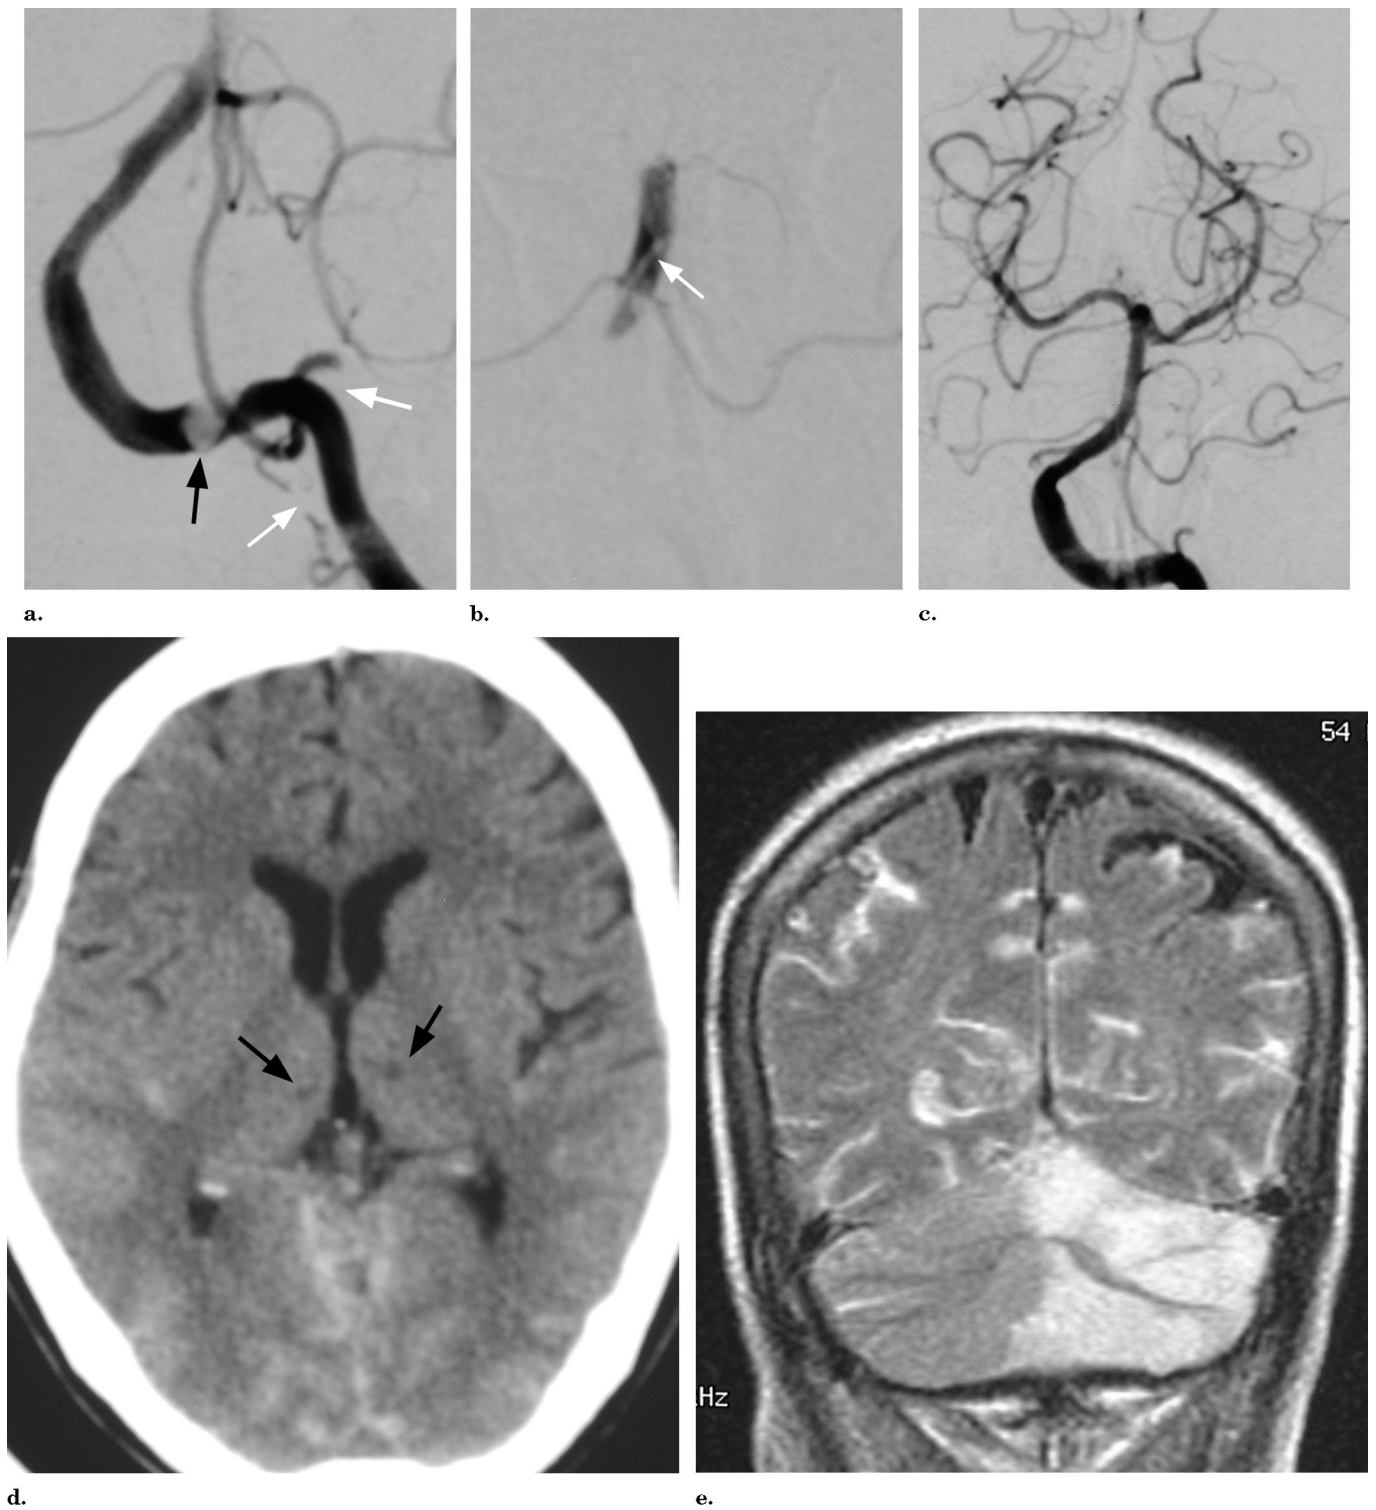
Images in a 55-year-old woman who presented with cranial nerve palsies and rapidly became comatose. (a) Towne projection of a left vertebral artery injection shows occlusion of the distal basilar artery. Note additional thrombus in the distal vertebral artery (black arrow) and posterior inferior cerebellar artery (white arrows). (b) A microcatheter was embedded into the distal, occlusive thrombus (arrow), and 900,000 U of urokinase was infused over 2 hours. (c) Left vertebral artery angiogram obtained after treatment shows recanalization of the distal basilar artery and filling of the posterior cerebral arteries bilaterally. (d) CT scan and (e) coronal fluid-attenuated inversion-recovery MR image obtained the following day reveal extensive infarction in the left cerebellar hemisphere and thalami (arrows in d) as well as diffuse subarachnoid hemorrhage. The patient was discharged with hemiplegia and dysmetria, and prolonged rehabilitation was required.
